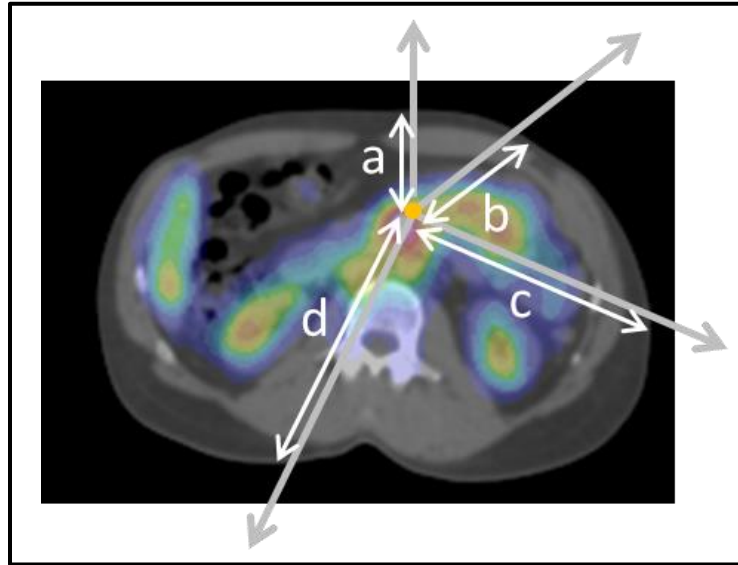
Non-uniform attenuation in SPECT.
